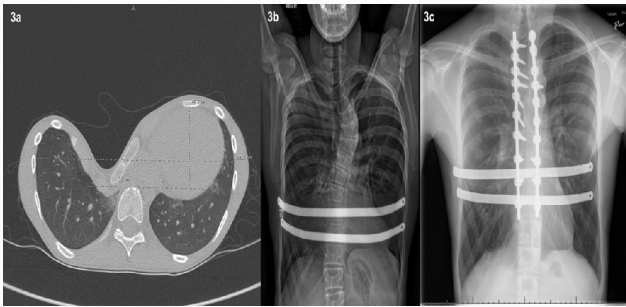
Preoperative and postoperative imaging of patient 3. Preoperative CT with HI of 76.7 (3a, left). Anterior XR (3b, middle) demonstrates PE correction with Nuss bars prior to scoliosis surgery. Anterior XR (3c, right) demonstrates both subsequent scoliosis correction.
